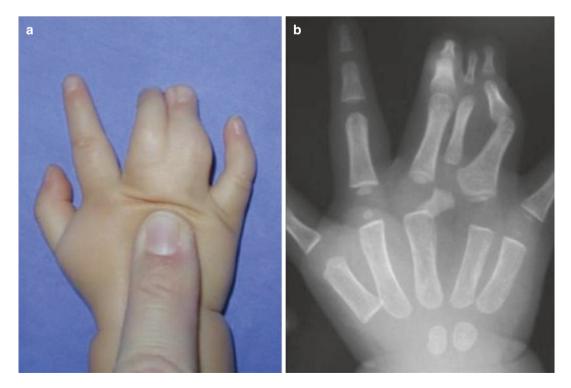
Synpolydactyly; (a) clinical picture, (b) x-ray
